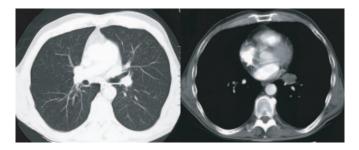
Thoracal computed tomography with contrast injection (slide thickness 7 mm): space occupying lesion in the left hilus, central discrete dorsal replacement of the vessels.
